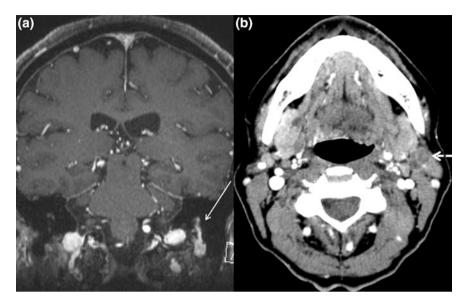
Adenoid cystic carcinoma. a Coronal fat-suppressed T1 post contrast. b Contrast-enhanced CT. Notice the heterogeneously enhancing lesion in the left parotid gland (dashed arrow in (b)). Perineural spread of tumor along the descending segment of the left facial nerve is seen (solid arrow) on image (a)
